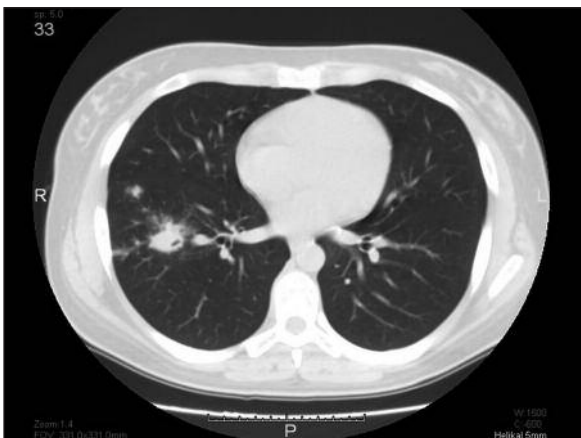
The air-filled cavitary lesion, and accompanying reticulonodular infiltration, tree-in bud appearance on right lower lobe on the thorax CT.
